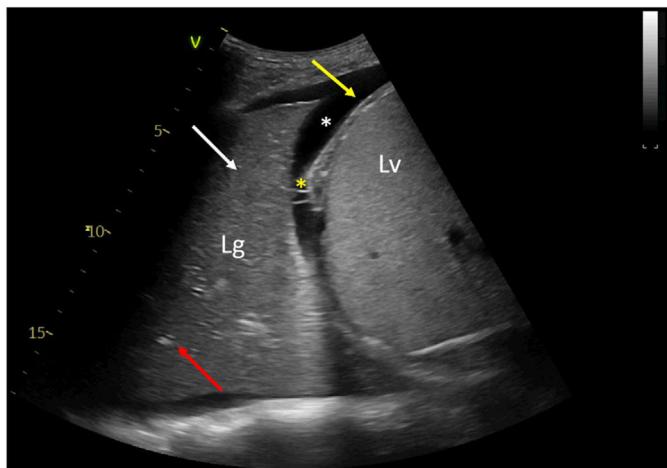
Lung ultrasound showing the diaphragm (yellow arrow), as well as lobar consolidation (white arrow), air bronchogram (red arrow), pleural effusion (white asterisk) and fibrin (yellow asterisk).
